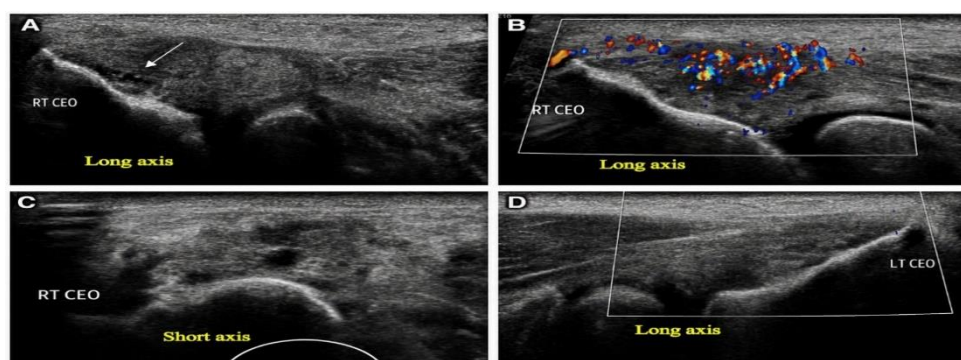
Ultrasonographic findings in right-sided severe lateral epicondylitis. (A) Long-axis view showing thickening of the right common extensor tendon (CET), measuring 6.8 mm, with diffuse hypoechogenicity and loss of the normal fibrillar pattern. An irregular hypoechoic area involving the middle and deep fibres at the enthesal attachment suggests an intrasubstance tear. Cortical irregularity of the underlying lateral epicondyle is also present. (B) Colour Doppler image demonstrating increased vascularity within the right CET, consistent with neovascularization. (C) Short-axis view of the right CET showing focal, rounded hypoechoic areas suggestive of micro-intrasubstance tears. (D) Long-axis view of the contralateral left CET showing normal morphology. Overall findings are consistent with right-sided severe lateral epicondylitis.
